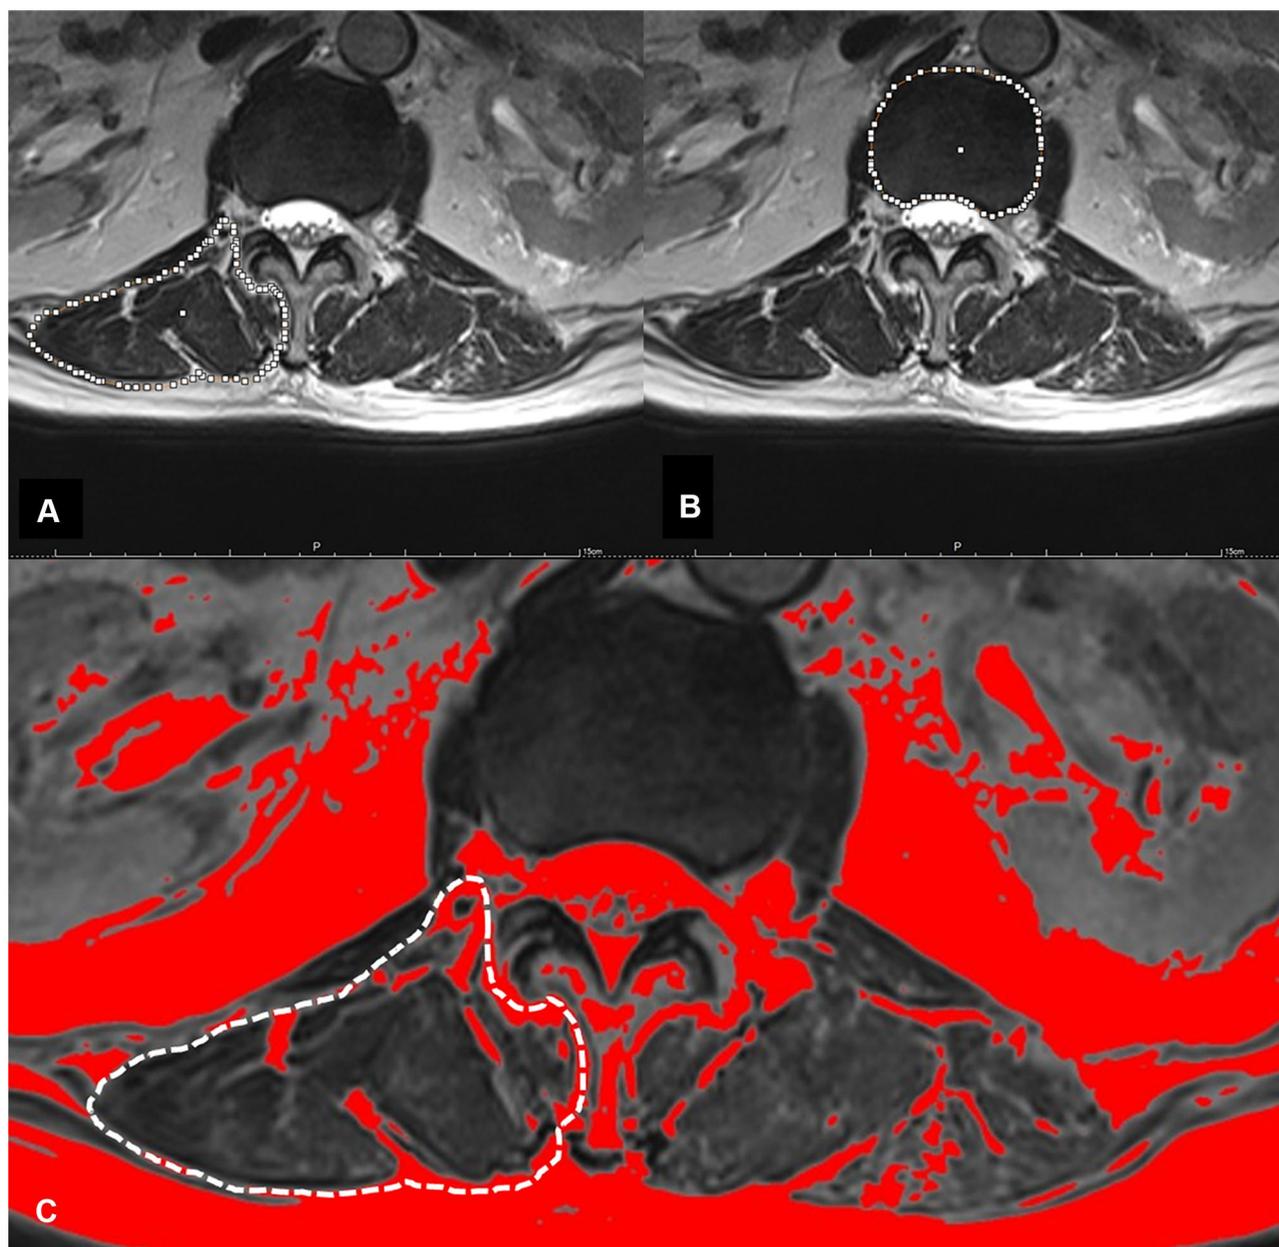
(A) The fascial boundary of lumbar paravertebral muscles (white circle). (B) The boundary of vertebral body (white circle). Muscle–disc ratio was (muscle area)/ (disc area): $19.53/16.30=1.20$. (C) Bright pixels of fat tissue in the MR images were colored in red (darker color in the black and white version) using pseudocoloring technique (threshold technique). The percentage of the red pixel area in the white circle was calculated (14.21%).
